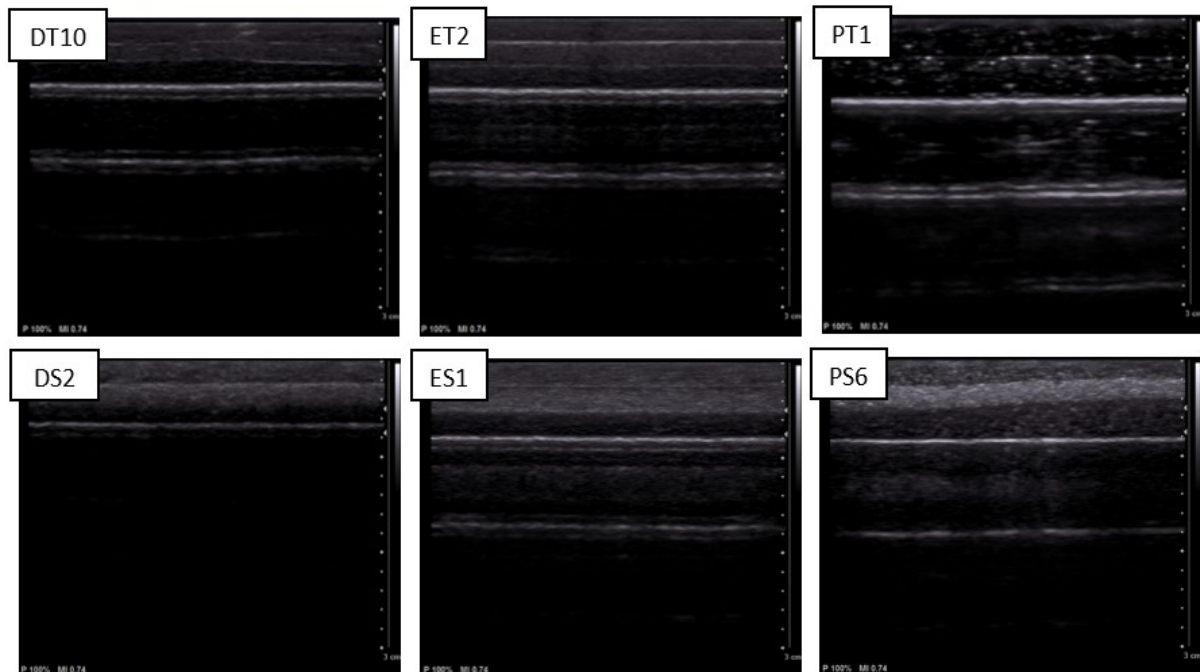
For every condition of the test pieces the selected ultrasound scan is shown. The labels correspond with the names of the test pieces addressed in table 3. The bright (white) line around 6 to 8 mm in depth represents the bottom surface of the test piece. Everything above this line represents the cross-section of the test piece. The samples were scanned with the muscularis propria layer on top. Therefore, the order in which the layers are represented in the ultrasound scans from top to bottom are: muscularis propria, lamina propria and urothelium. The three-layered structure is clearly visible for every test piece, except for test piece PT1.
